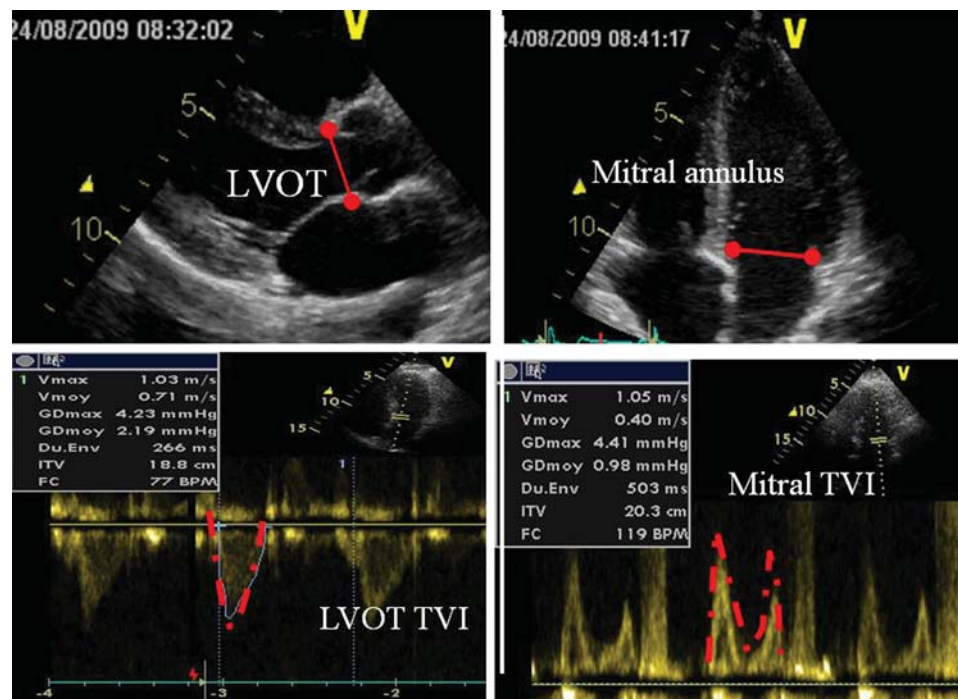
The quantitative assessment of aortic/pulmonary regurgitation severity by the Doppler volumetric method requires the measurement of the left ventricular outflow tract diameter (LVOT), the mitral annulus diameter and of two pulse wave velocity profiles (outflow tract and mitral inflow velocities). TVI, time–velocity integral.
